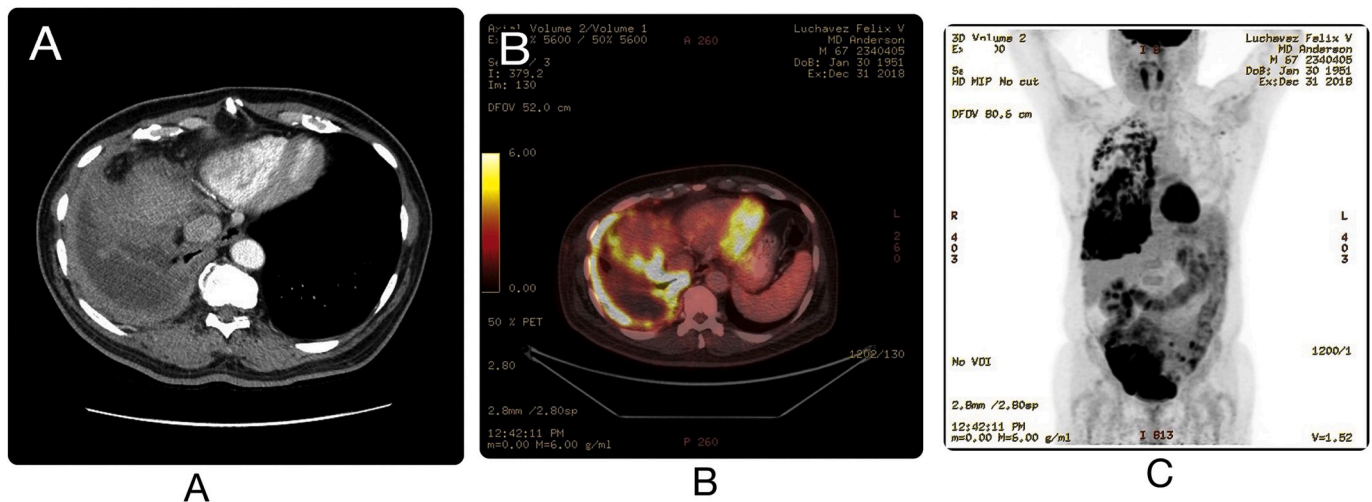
A Computer tomography (CT) of the chest showing a complex appearing small right pleural effusion surrounded by thickened pleura with significant nodularity. B PET-CT showing increased FDG avidity along nodular right pleural thickening, including mediastinal pleural. C PET-CT(coronal view) showing increased FDG avidity along nodular right pleural thickening, including mediastinal pleural.
